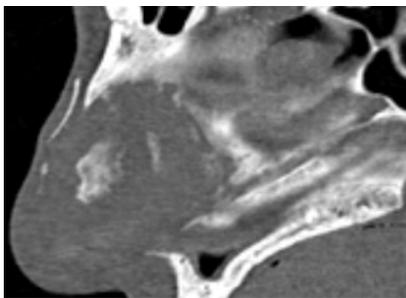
Sagittal CT scan. Two years after the surgery: the normal anatomy of the NS.
